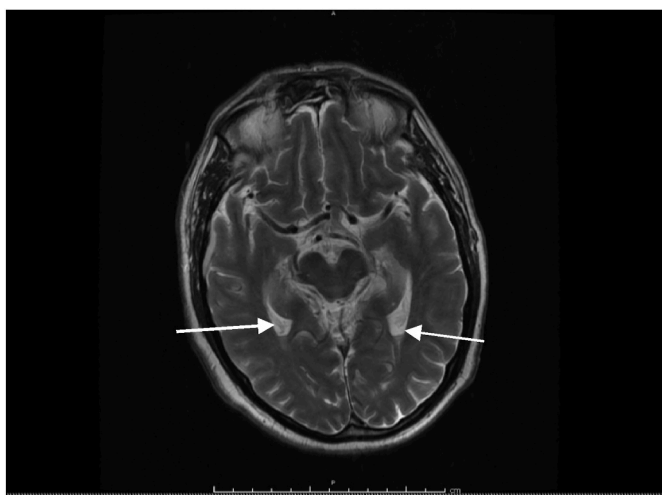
MRI showing layering debris (arrows) within the occipital horns of the lateral ventricles with diffusion restriction consistent with ventriculitis [1].
